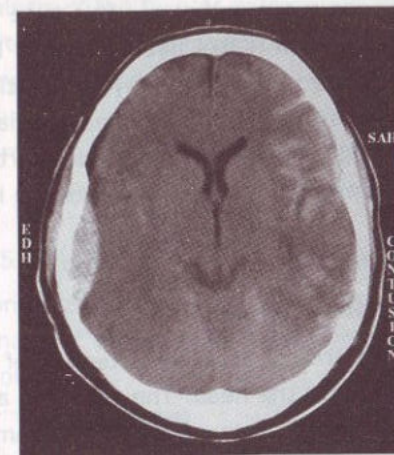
CT scan showing traumatic SAH on left side and thin EDH on right side
